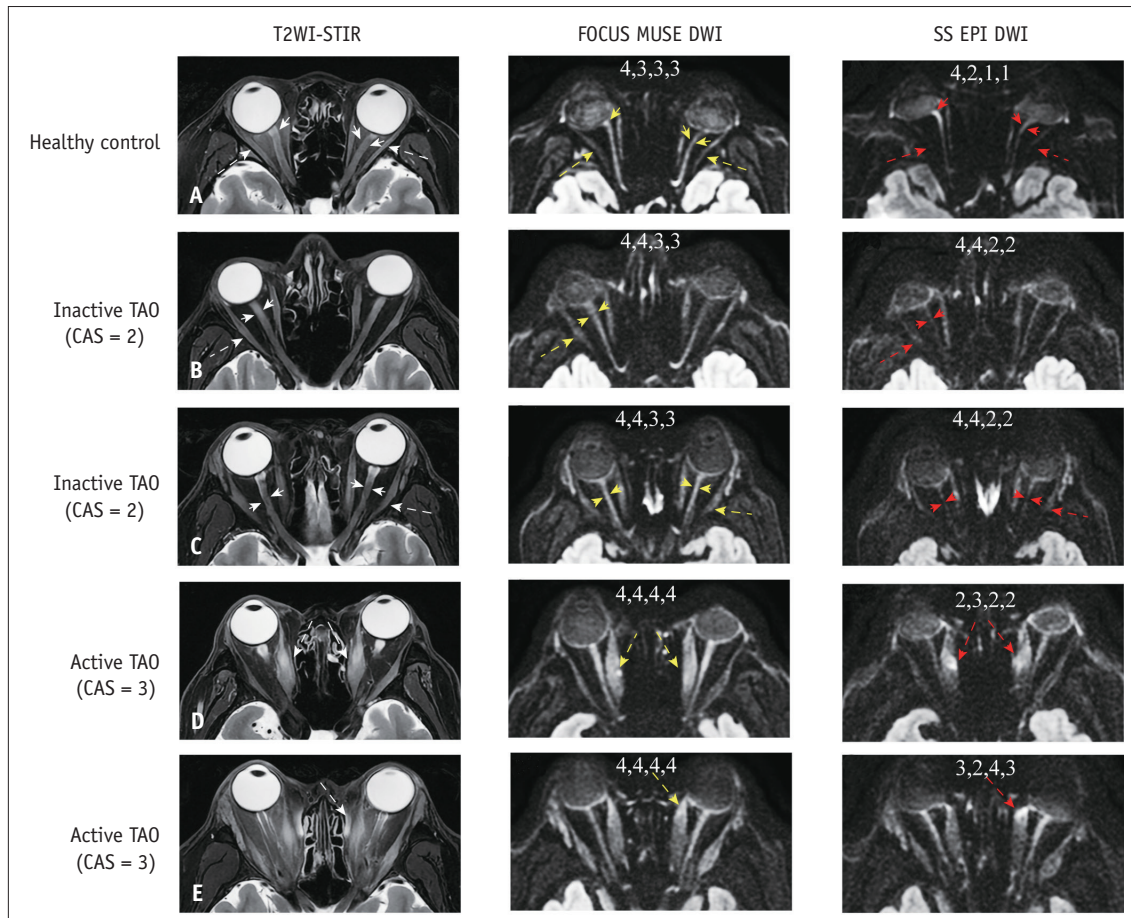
Images from representative healthy controls and patients with inactive and active TAO. A: Middle image shows mild optic nerve distortion (yellow arrows) and clearly depicts LRMs (yellow dotted arrows). However, right image shows moderate optic nerve distortion (red arrows) and unclear LRMs (red dotted arrows). B: Middle image shows clear optic nerves (yellow arrows), and the LRM is delineated (yellow dotted arrow). Conversely, right image shows a blurry optic nerve (red arrows) and indistinct LRM (red dotted arrow). C: Middle image shows clear optic nerves (yellow arrows), and the LRM is displayed intact (yellow dotted arrow). In contrast, right image shows unclear optic nerves (red arrows) and an incomplete LRM (red dotted arrow). D: Middle image has no artifacts (yellow dotted arrows), whereas right image shows moderate artifacts in the MRMs (red dotted arrows). E: Middle image has no artifacts or distortions (yellow dotted arrow), while right image shows mild artifacts and distortion (red dotted arrow) in the MRM. The numbers within each diffusion-weighted image represent the visual image quality score of susceptibility artifacts, sharpness of boundaries, geometric distortion, and overall image quality. To clarify the structures marked by arrows in the DWI maps, T2WI-STIR images were referenced. Thus, the yellow and red arrows in FOCUS MUSE DWI and SS EPI DWI match the structures indicated by white arrows in T2WI-STIR images, while the yellow and red dotted arrows correspond to the structures shown by white dotted arrows in T2WI-STIR images. TAO = thyroid-associated ophthalmopathy, LRM = lateral rectus muscle, MRM = medial rectus muscle, T2WI-STIR = T2-weighted imaging with short tau inversion recovery, FOCUS MUSE = field-of-view optimized and constrained undistorted single-shot multiplexed sensitivity-encoding, DWI = diffusion-weighted imaging, SS EPI = single-shot echo-planar imaging, CAS = clinical activity score
